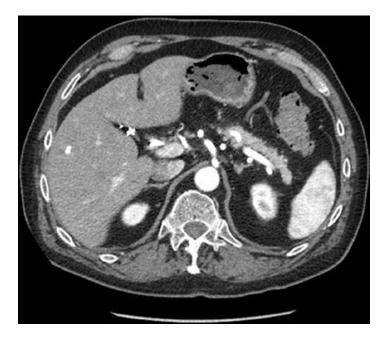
CT scan demonstrating regression of the inflammatory changes in the patient after treatment with corticosteroids
